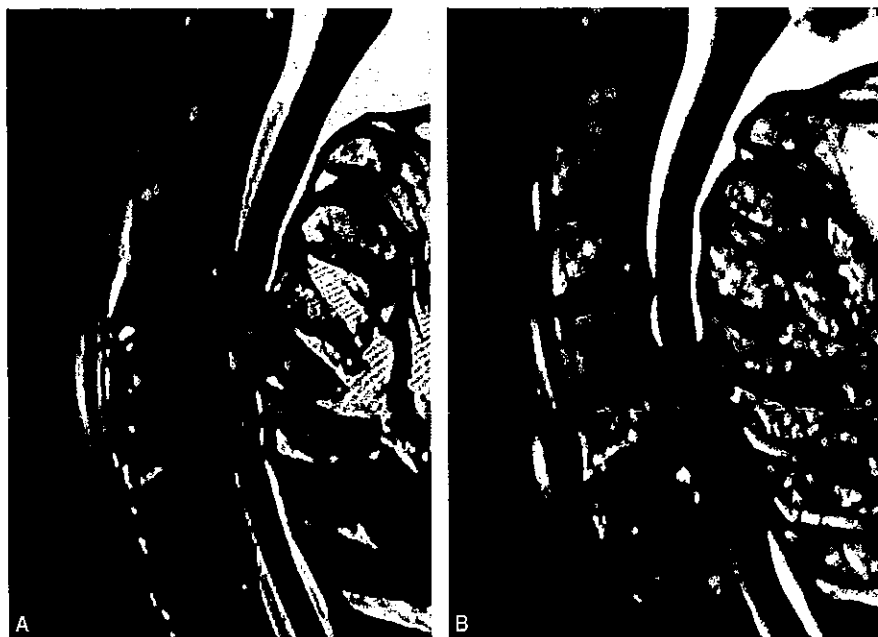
"Hematoma-like changes" and the level of injury on MRI. A, MRI findings of a hypointense core surrounded by a hyperintense rim in a T2-weighted image. We described these changes as "hematoma-like changes." When these changes were present, the level of the changes served as the level of injury on MRI. This patient's level of injury on MRI was "C3/4". B, When hematoma-like changes were absent, the segment containing the center of a wider-ranging hyperintensity area served as the level of injury on MRI. This patient's level of injury on MRI was "C5/6." MRI indicates magnetic resonance imaging.
